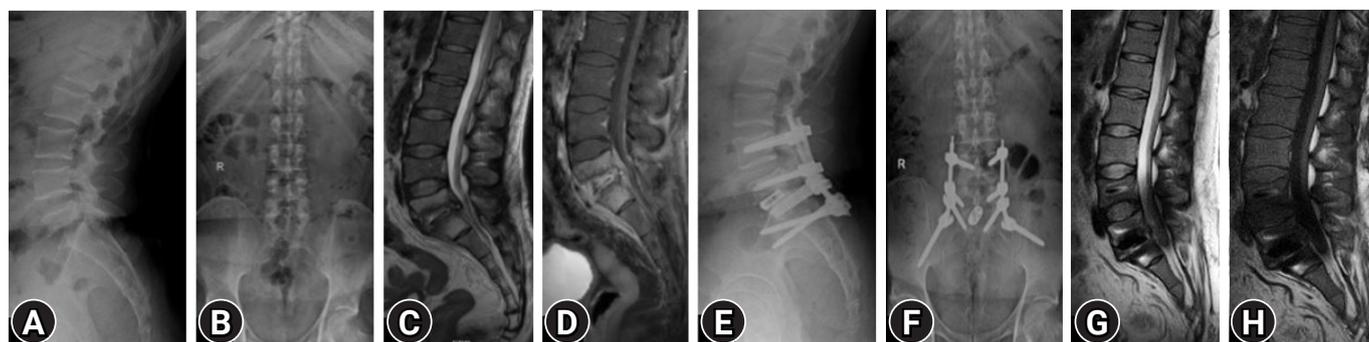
Case example 3. (A, B) Preoperative AP/lateral X-rays showing with endplate irregularity (L5 lower and S1 upper endplate). (C, D) Preoperative MRI-Sagittal T2 and T1+C showing signal changes in vertebral bodies with erosions of adjoining endplates involving L5 & S1 and the intervening disc with epidural collection causing compression on thecal sac and nerve roots. (E, F) Post-operative X-rays AP/lateral at one month showing L4–L5 interbody cage, pedicle, and iliac screw at 1 month. (G, H) Post-operative MRI sagittal T2, T1 at 6 months revealing remodelling of L5, S1 vertebral body with no evidence of epidural collection.
